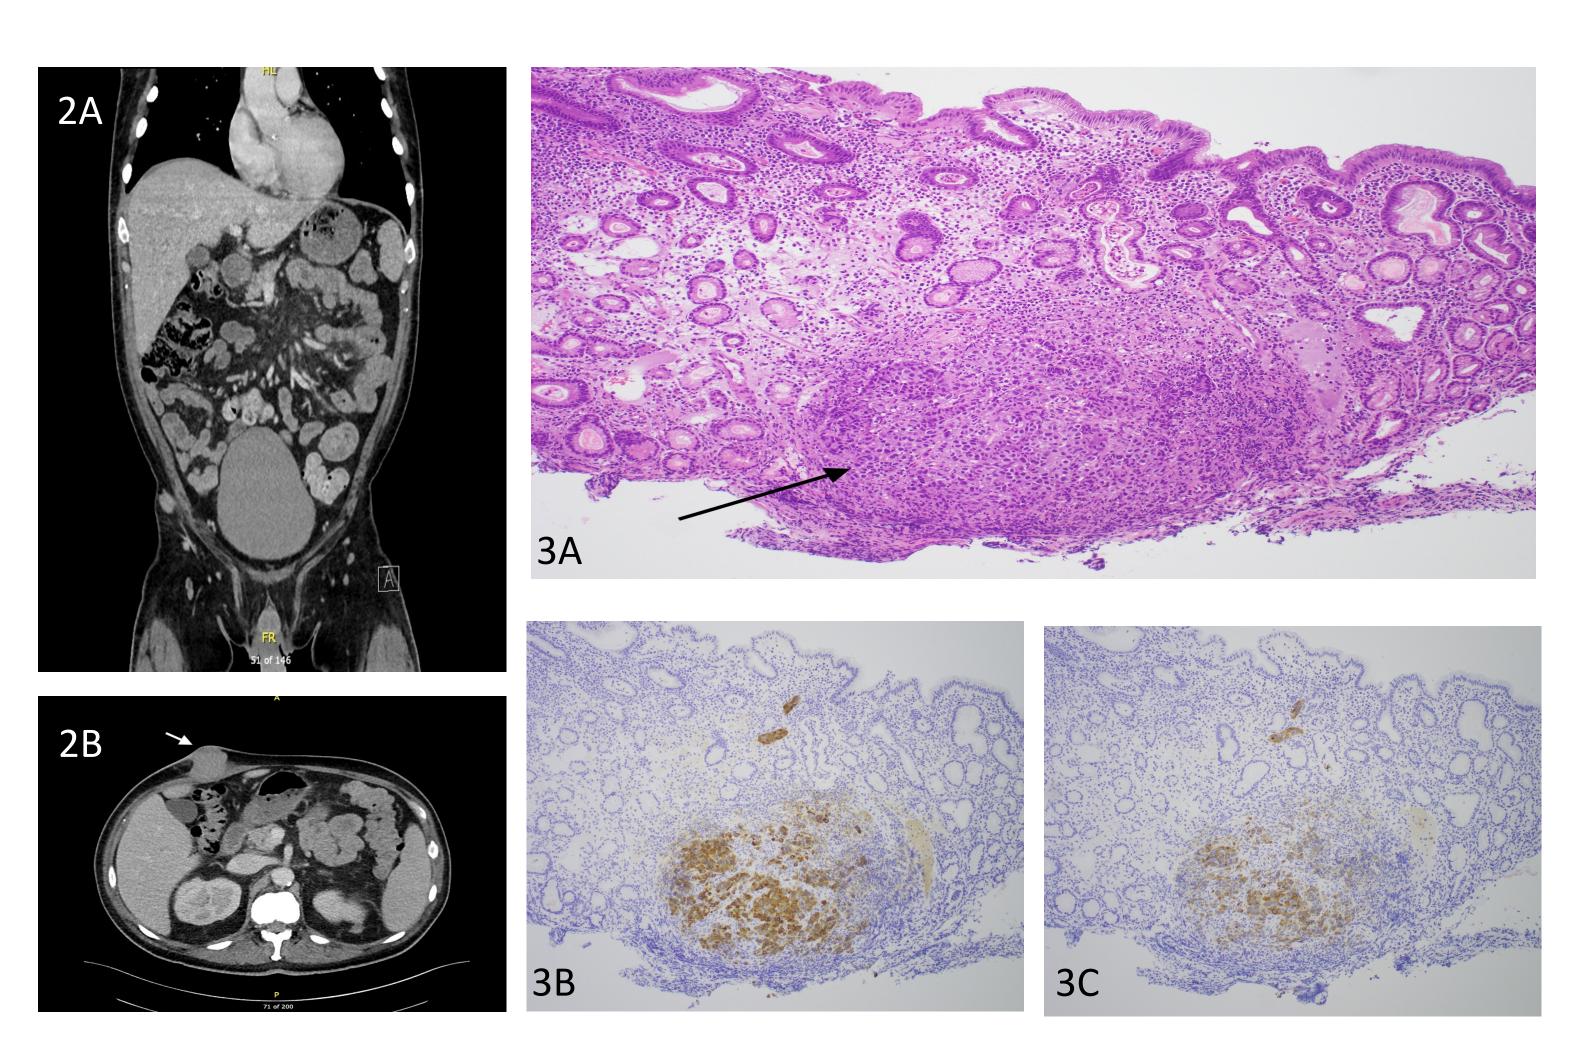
A) Coronal CT image showing multifocal metastatic disease of unknown origin, small bowel carcinomatosis. B) Axial CT image showing dominant lesion (arrow) in the right upper abdominal wall.
